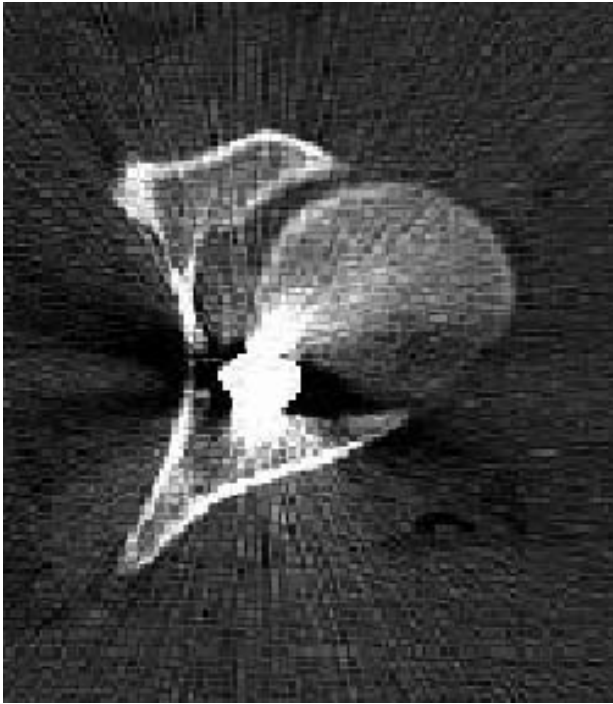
Axial view of CT scan. Bullet fragment location is identified.
